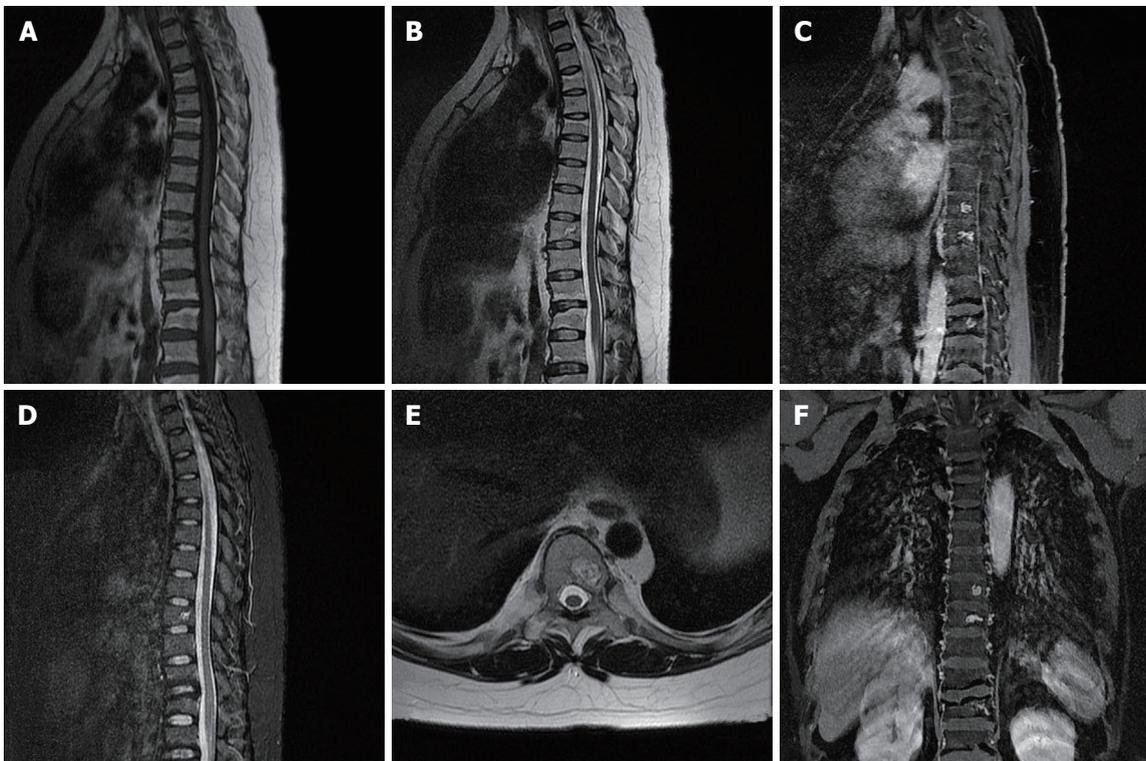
Spine magnetic resonance imaging of Patient 1. A-F: Patchy bone lesions that were of low signal intensity on T1WI (A), mixed signal intensity on T2WI in sagittal (B), axial (E), and coronal images (F), and high signal intensity on fat saturated T2WI (C) with enhancement on gadolinium enhanced T1WI (D).
